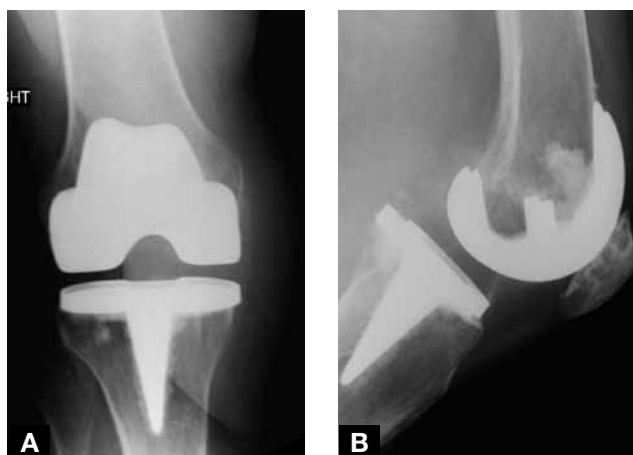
(A, B) At 18 years, radiographs of NK-I system with cemented fixation of femoral component and tibial baseplate without peripheral pegs.
